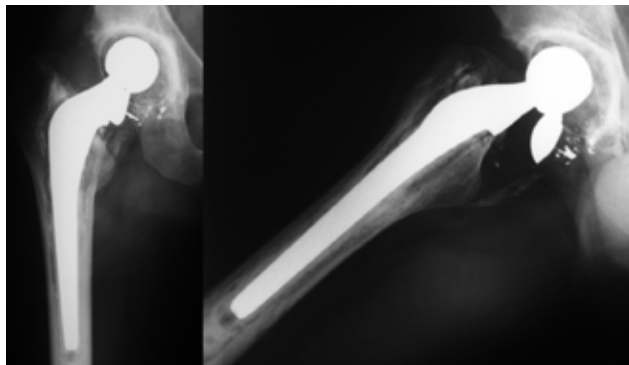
Preoperative radiograph, demonstrating fracture of the head, aseptic loosening of femoral component, and liner wear. Note that the greatest fragment remains attached to the taper.
